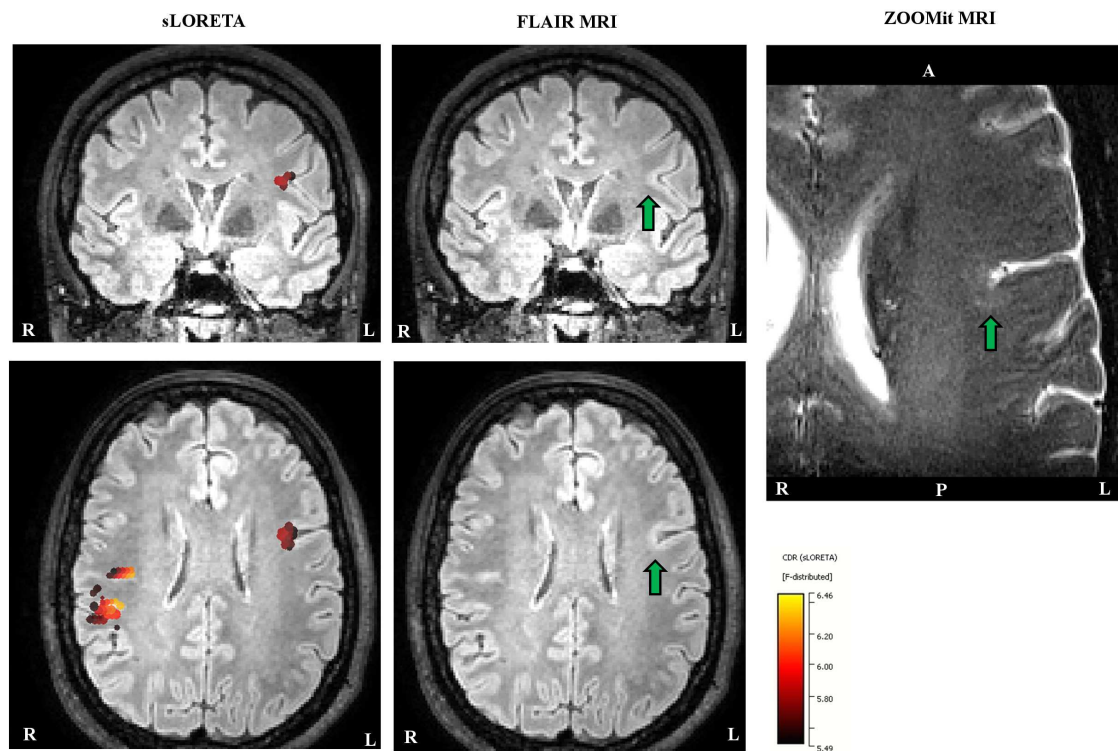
Source localizations at -23 ms, slices selected according to the left hemispheric activity. In the left column, the sLORETA results registered to the FLAIR MRI are shown (only results obtained with a threshold of 85 % for the maximum F-value are shown). In the middle column, the FLAIR image without localizations is shown. The right column shows the ZOOMit MRI for the localization cluster (detected with sLORETA) at the left fronto-central region. The green arrows show the FCD and the white letters on MRIs indicate the orientation (L: Left, R: Right, A: Anterior, P: Posterior).
